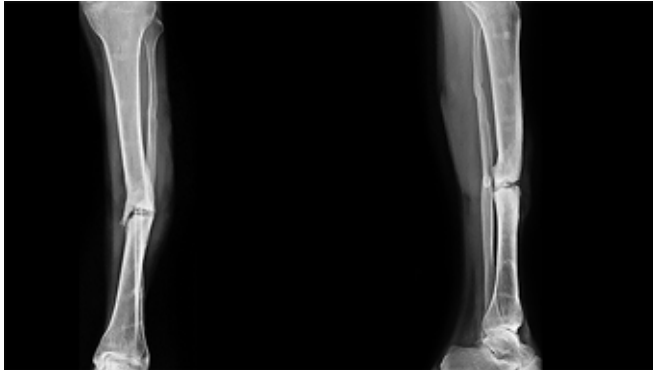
X-ray leg AP and lateral views showing nonunion of midshaft fracture of tibia.
